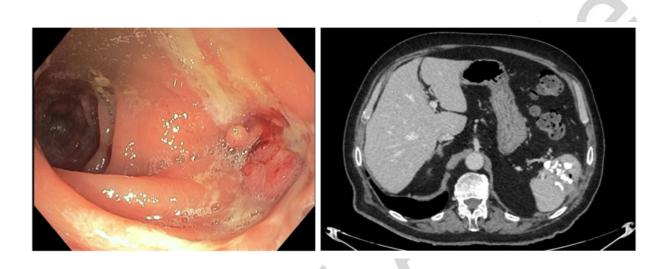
On the left, a colonoscopy image showing a fistulous opening with surrounding granulation tissue and the discharge of purulent material. On the right, an abdominal CT image showing a splenic cyst with coarse calcifications and intra-cystic gas.
